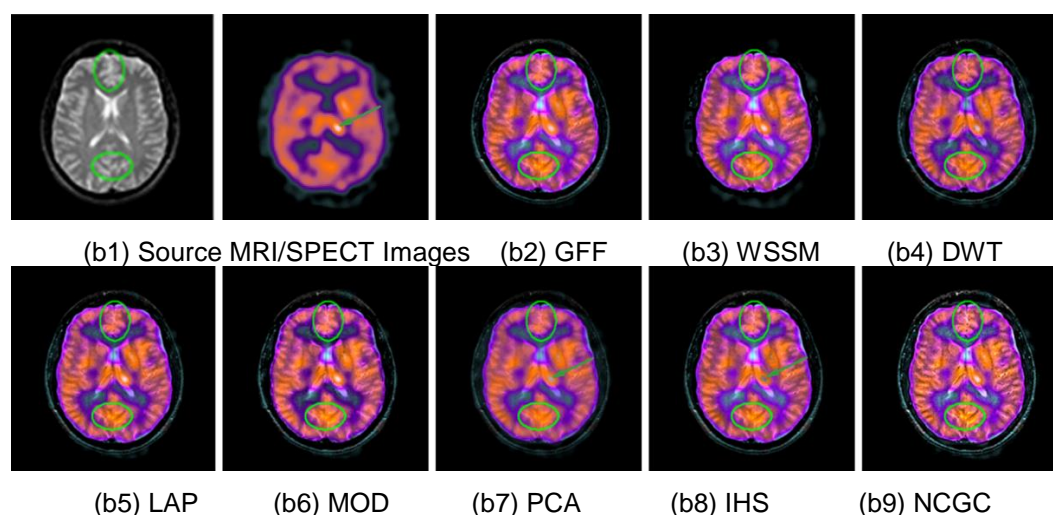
Performance Comparison of different Fusion Methods in CT/MRI
